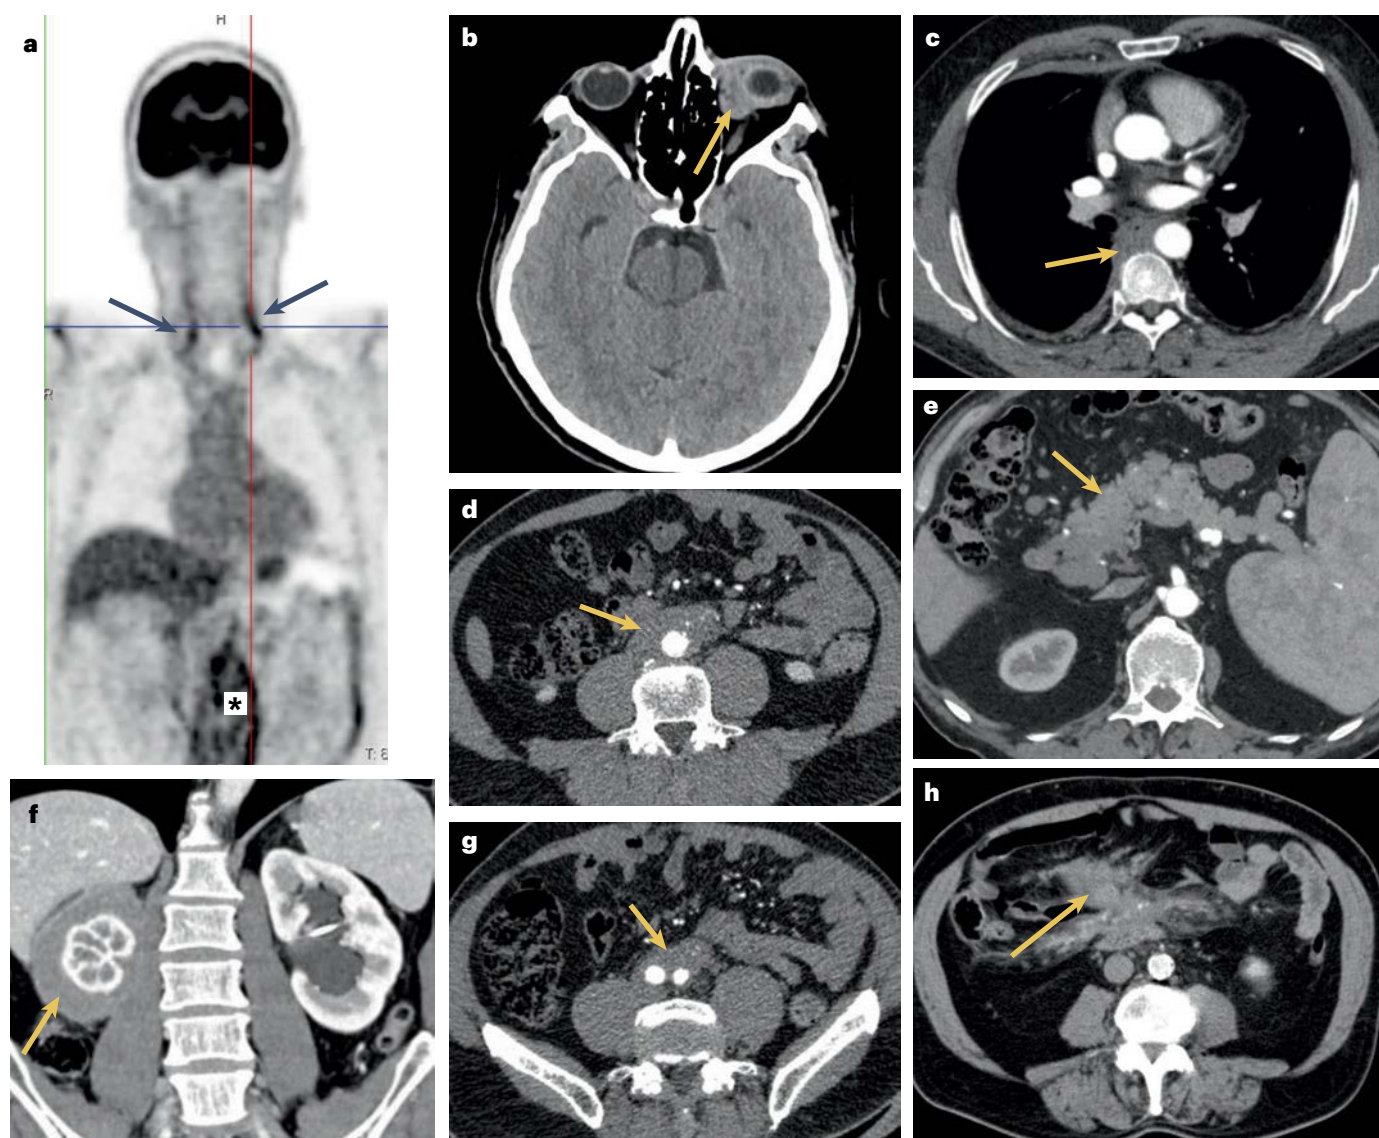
Radiological findings in IgG4-related disease. a, PET image (coronal view) showing increased uptake of fluorodeoxyglucose around the abdominal aorta (asterisk) and the common carotid arteries (arrows). b, Head CT image (axial view) showing orbital involvement (arrow). c, CT image of the chest (axial view) showing mediastinal fibrosis, which appears as a pre-vertebral, muscle-isodense tissue (arrow) adjacent to the descending thoracic aorta. d, Abdominal CT image (axial view) showing peri-aortitis (arrow) developing on the antero-lateral sides of the abdominal aorta. e, Abdominal CT image (axial view) showing
